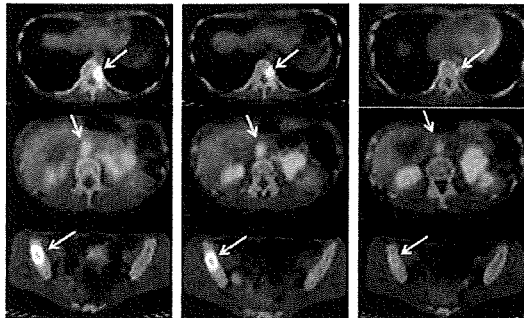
治療前後のFDG-PET/CT (横断像) 所見
